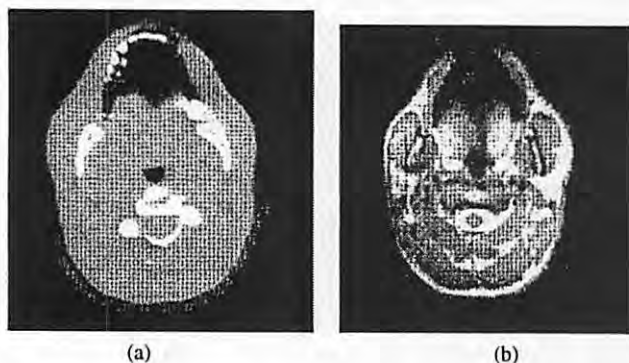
Axial slices from the oral region of the vocal tract for the vowel /a/: a) EBCT, b) MRI.
